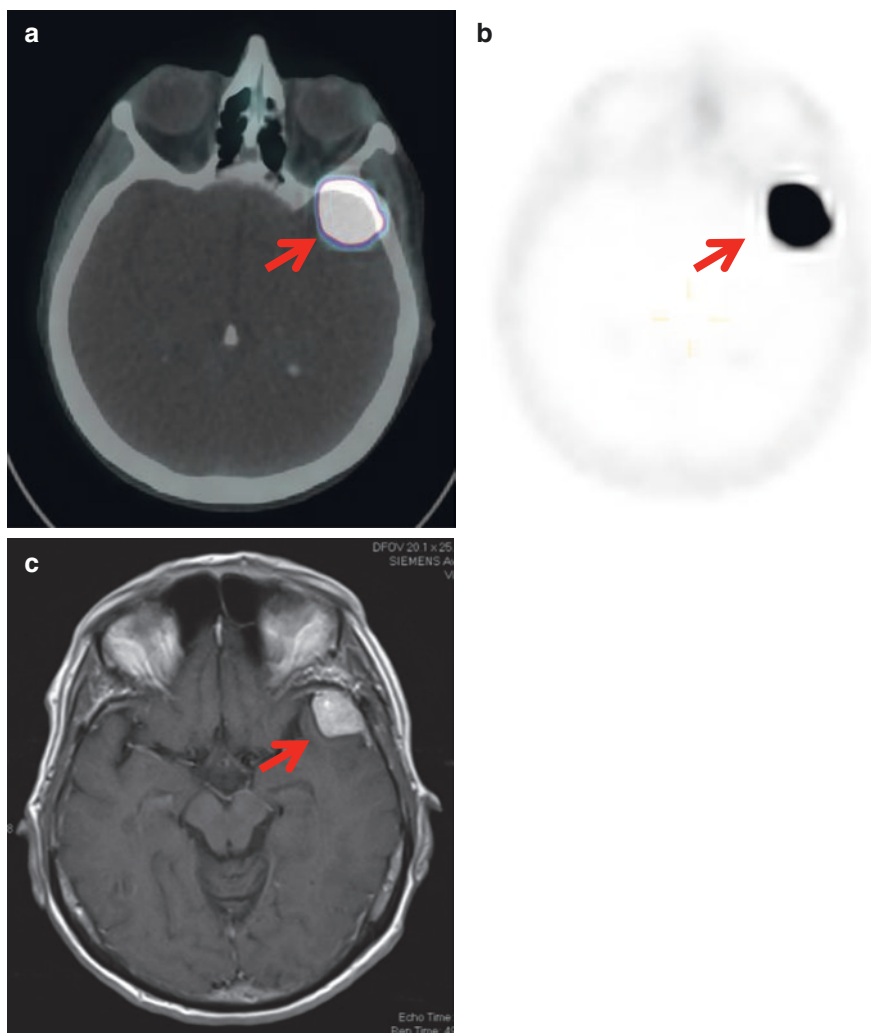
(a–c) Axial fused ^{68}Ga DOTATATE PET/CT(a), axial ^{68}Ga DOTATATE PET (b) and contrast-enhanced T1WI MRI (c) show ^{68}Ga DOTATATE intensely avid left temporal fossa lesion (a, b arrows) corresponding to an enhancing left temporal extra-axial lesion on MRI (c, arrow) in which the differential included dural-based metastasis and meningioma. The remainder of the ^{68}Ga DOTATATE PET/CT did not show uptake elsewhere, and findings were keeping with a meningioma.
